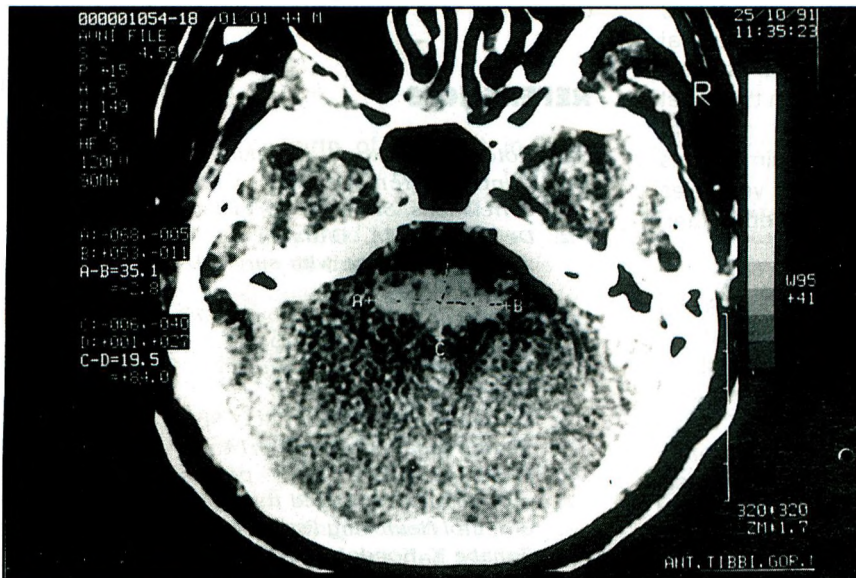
CT scan taken after two hours from the onset.
